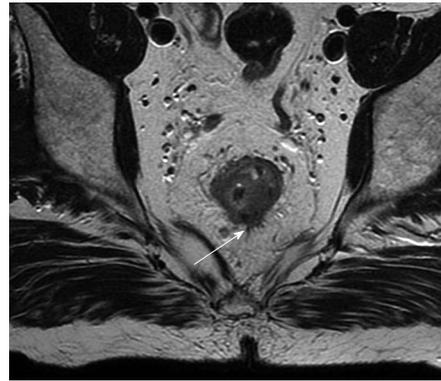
Magnetic resonance imaging (arrow) showing possible extension beyond the muscularis propria, radiologically staged as early T₃.
